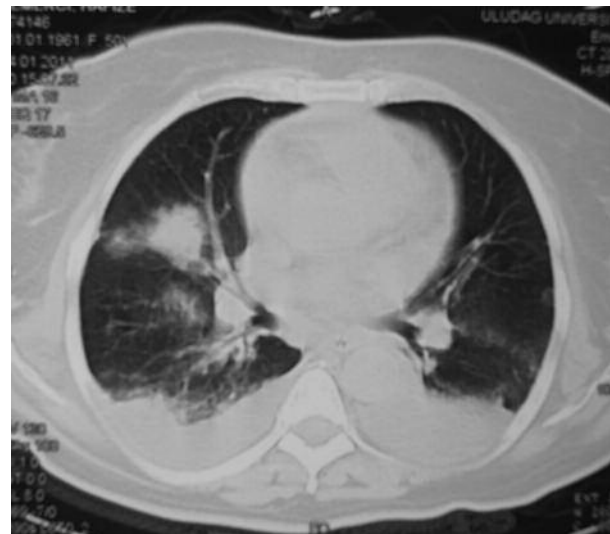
CT scan of the lungs shows multiple consolidated areas and nodules and note also the bilateral pleural effusion.
